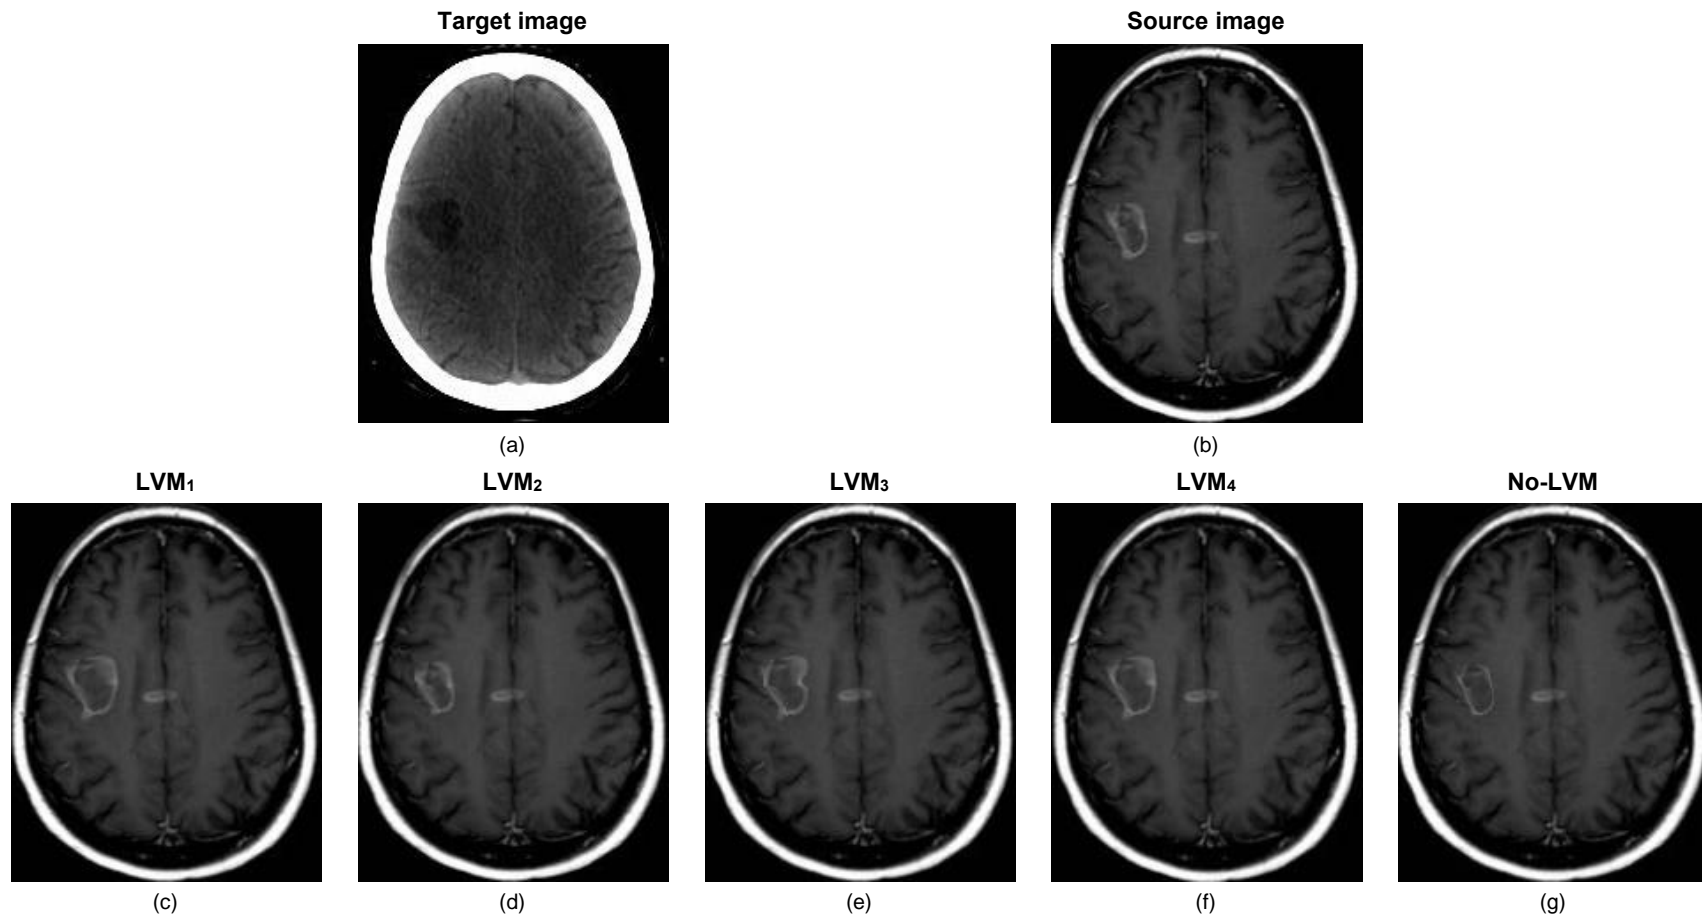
Registration results for the four LVMs and No-LVM version. (a) and (b) CT-Pre and MR-Post images used as target and source, respectively; (c)-(g) registered images, and (h)-(l) deformation fields after NRR.
